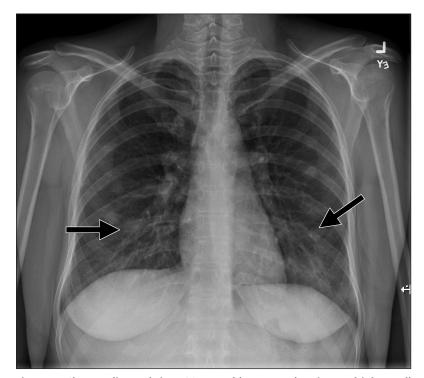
Chest radiograph in a 30-year-old woman showing multiple small nodular lesions bilaterally (arrows).
